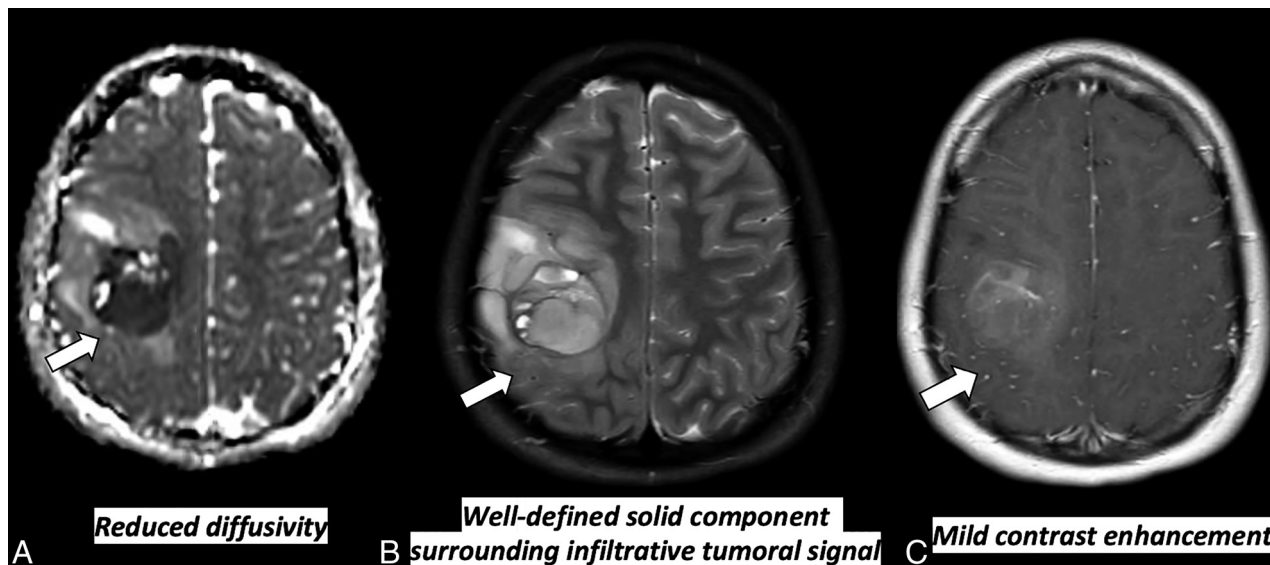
Seventeen-year-old with *H3* G34 mutant tumor. ADC map, T2-weighted, and T1-weighted postcontrast axial images of the brain show a well-defined solid, cortically involved tumor in the right parietal lobe (white arrow) with surrounding infiltrative tumoral signal involving the overlying cortex.
